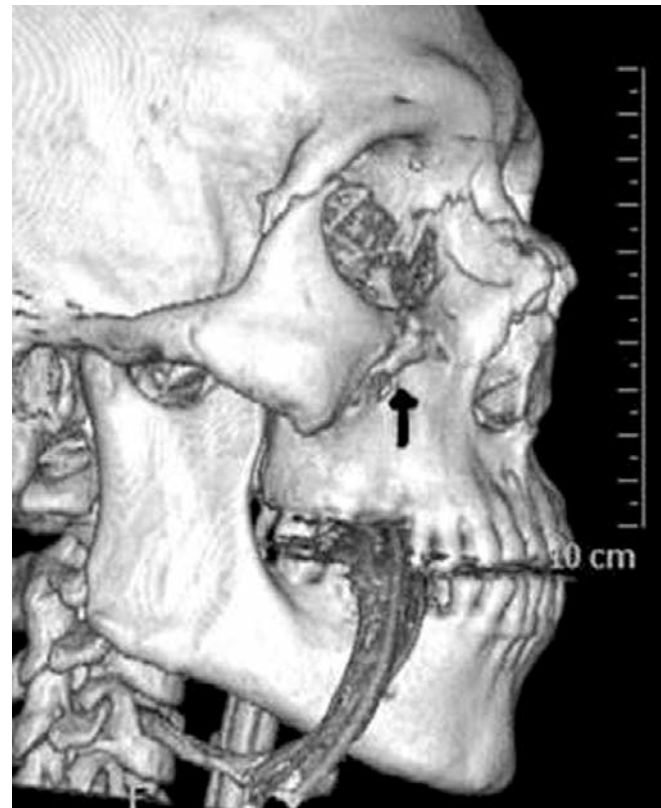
Preoperative 3D CT image showing right zygomatic complex fracture (arrowed) orbital floor and nasal fractures.
